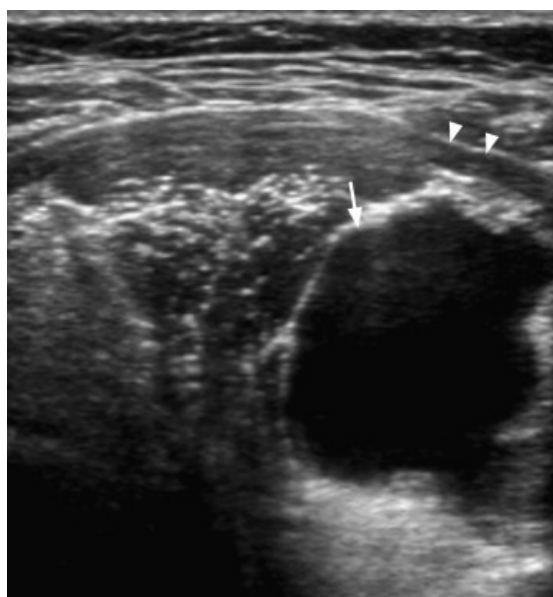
Ultrasound image of ranula.
